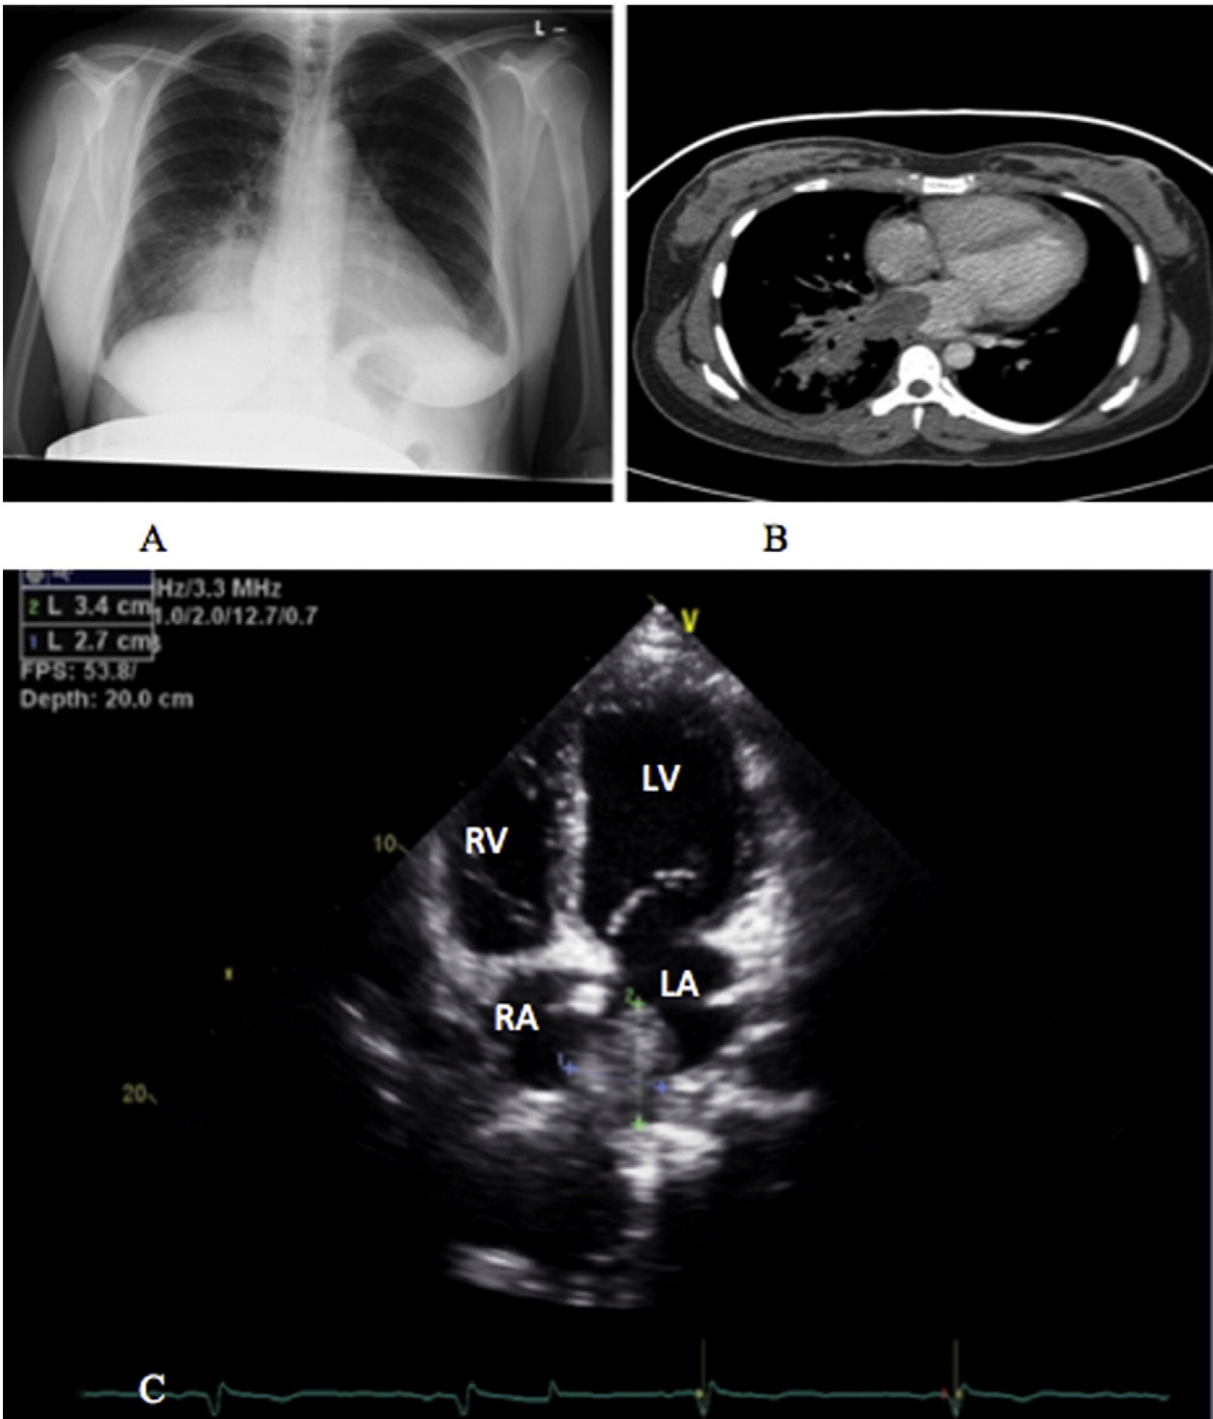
A: Initial CXR: large right lower lobe pulmonary mass with mediastinal extension B: CT chest: 7 cm right lower lobe mass with extension to the left atrium via the pulmonary veins C: Transthoracic echocardiogram: 2.7 cm × 4.5 cm mass in left atrium obstructing pulmonary venous inflow from left middle and lower pulmonary veins.
